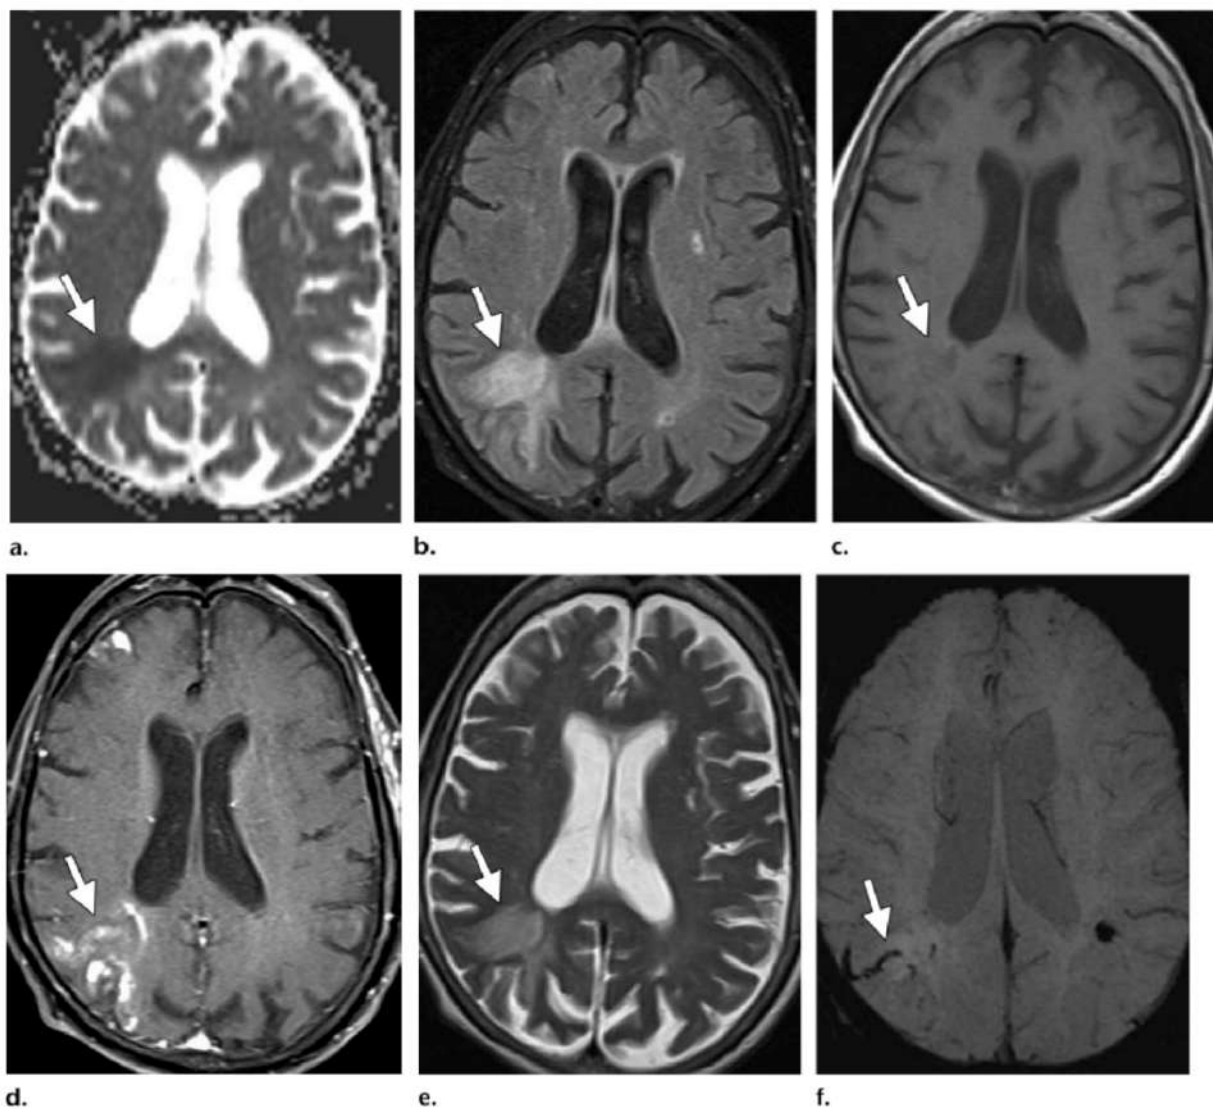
MRI sequences in acute ischemic stroke
